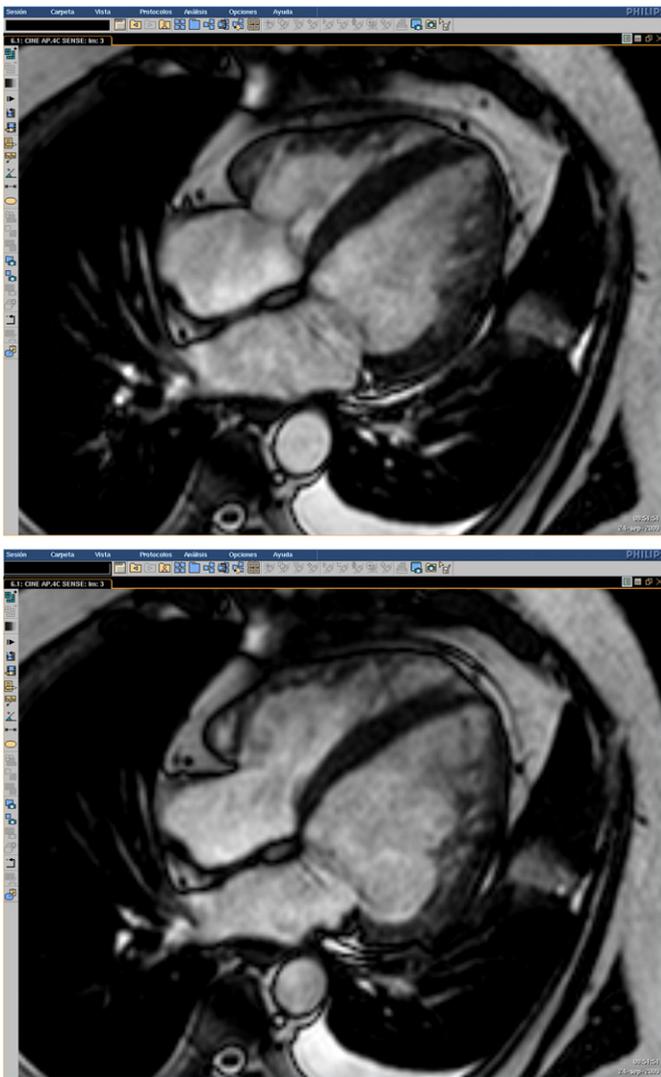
MRI performed on admission, cine images obtain.
